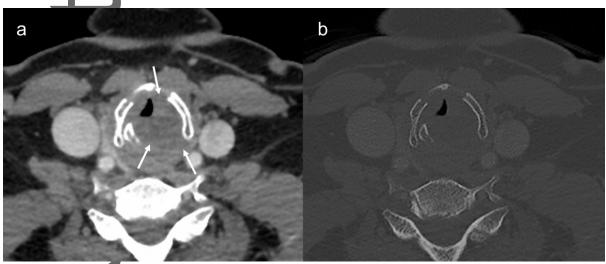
A laryngeal chondrosarcoma in a 36-year-old male patient (case 12). Contrast-enhanced CT (a) shows a lobulated mass (arrow) with a well-defined margin on the left side of the cricoid cartilage with minimal enhancement, calcification, and cortical defect/expansion. Bone window CT (b) shows coarse, granular calcification (within the circle) inside the lesion
